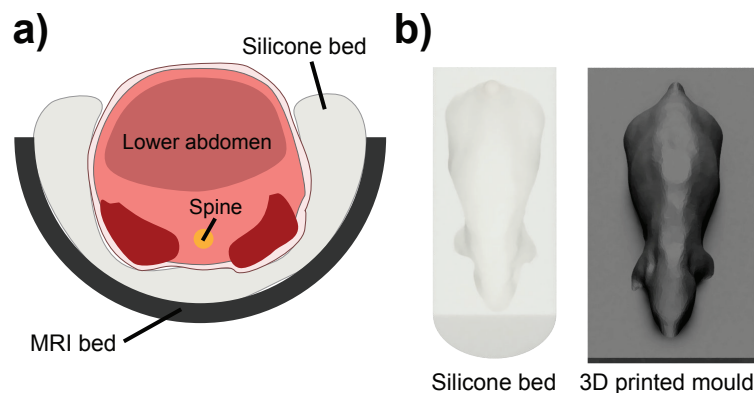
Novel MRI holder geometry. (a) Design of the silicone holder to achieve a comparable anatomical cross-section within MRI and MSOT. (b) Rendering of the silicone bed and the corresponding 3D printed mold.
